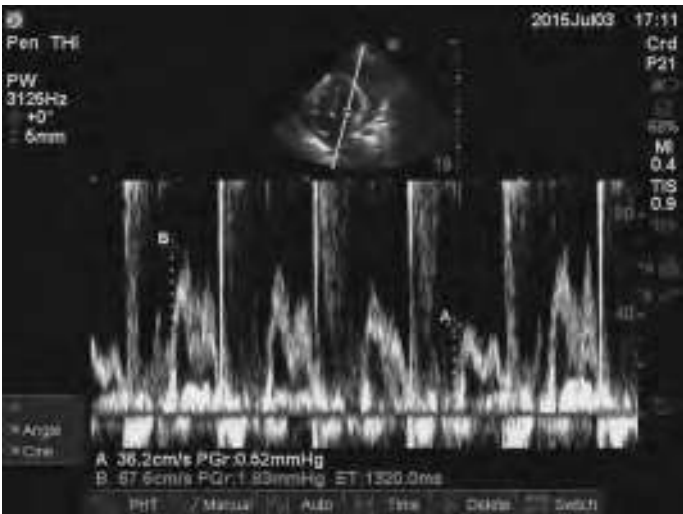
US apical four-chamber view with the Doppler sample gate placed at the tip of the mitral valve leaflets. Variation of the E wave is noted over the respiratory cycle with the lowest and highest velocities recorded as A and B, respectively. The difference between the two (36.2 cm/s and 67.6 cm/s) is 54%. Greater than 25% difference represents sonographic pulsus paradoxus. (Photo used with permission from reference 47.)
